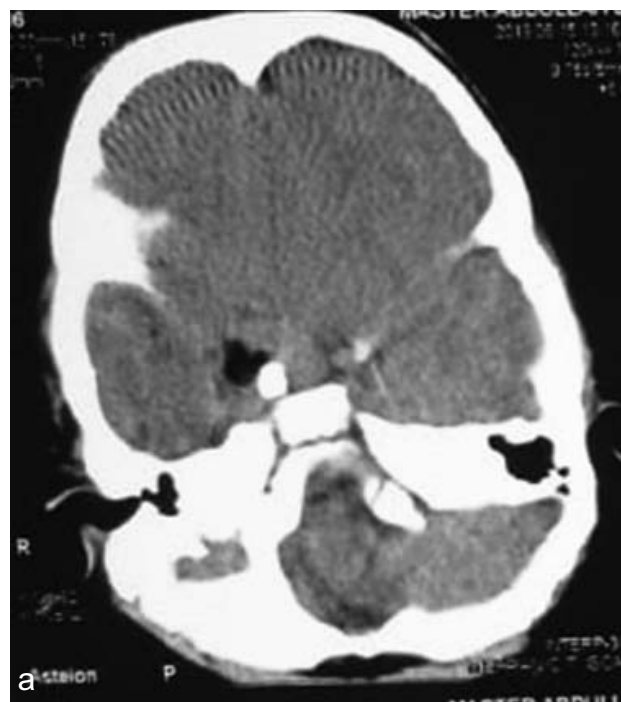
CT Scan Brain Axial view: A solid hypodense mass is seen involving the sellar extending to suprasellar region. It shows a calcifying component with a small fat density within it. It approximately measures 4.3 x 3.8 x 3.5 cm (APxTSxCC). Findings represent dermoid, possibility of craniopharyngioma was also kept in differential.
